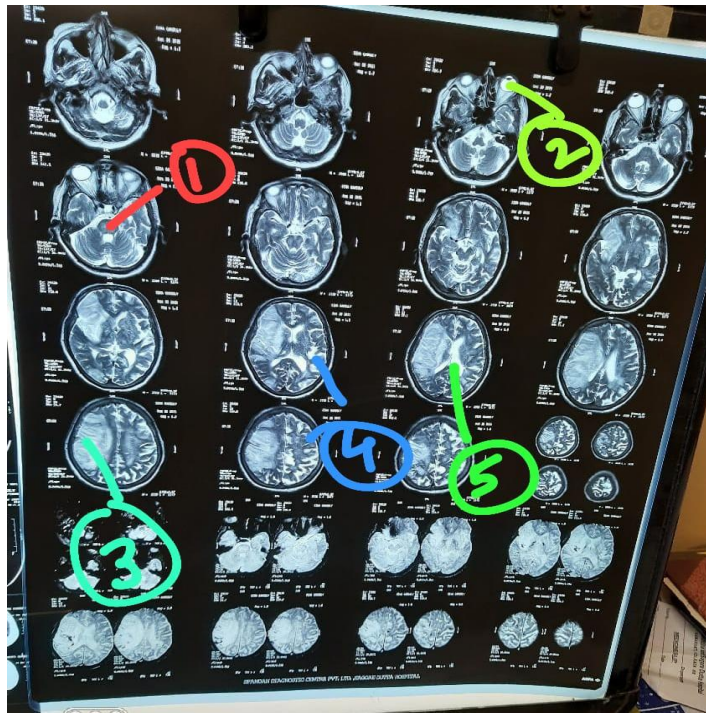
This is a T2w MRI OF MRI (transverse section). It shows an Ischemic area in the right cerebral hemisphere (1. Midbrain, 2. Eyeball within orbit, 3. Ischemic Area, 4. Insular Cortex, 5. Lateral Ventricles) (Source: Real MRI images captured through mobile phones)
